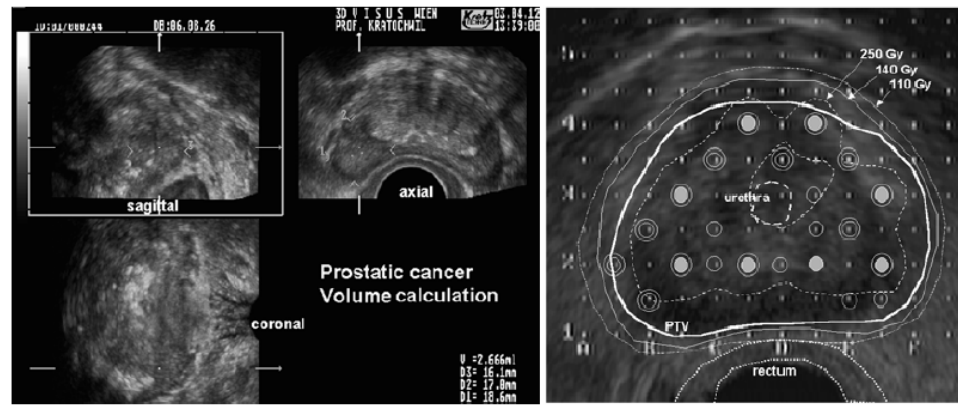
(Left) Transverse endorectal ultrasound image displaying the dimensions of the prostate (width and thickness) as well as the urethra and the rectum. In addition, there is evidence of gross tumour in the right posterior-lateral part of the prostate. (Right) The distribution of I-125 in the ultrasound prostate volume study. The prostate, the PTV, the urethra, and the rectum are delineated. The number of seeds in the volume and their topographic position within the 3D coordinate system can be precisely calculated, determined and displayed in different orientations. Isodose lines are shown in relation to the PTV (V100). Certain dose constraints for the urethra and rectum must be taken into account (6).
